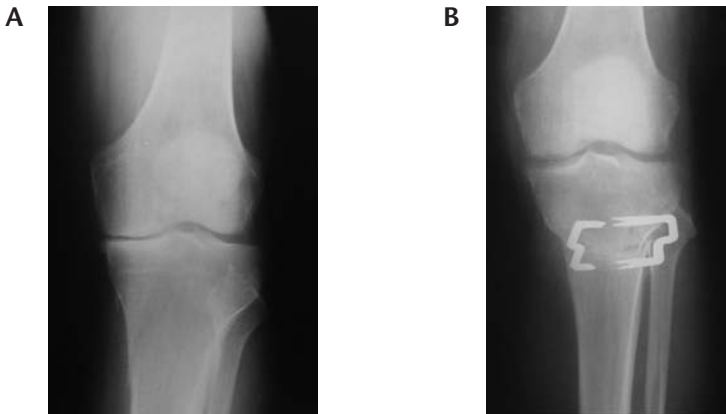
Radiographs of the left knee in a 54-year old male with medial compartment osteoarthritis. (A) Preoperative standing anterior–posterior radiographs showing medial joint space narrowing and varus deformity. (B) Standing anterior–posterior radiographs 46 months postoperative to focal dome osteotomy with fixation by three U-staples showing union on the osteotomy line and adequate correction of the varus deformity
